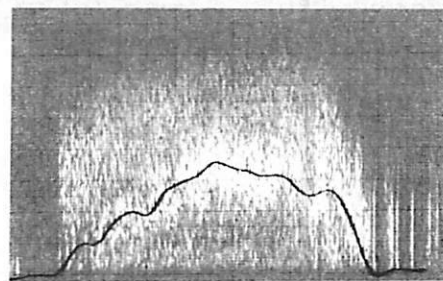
Ridge tracing applied to the Doppler spectrogram. This makes the "4" of fig.5
